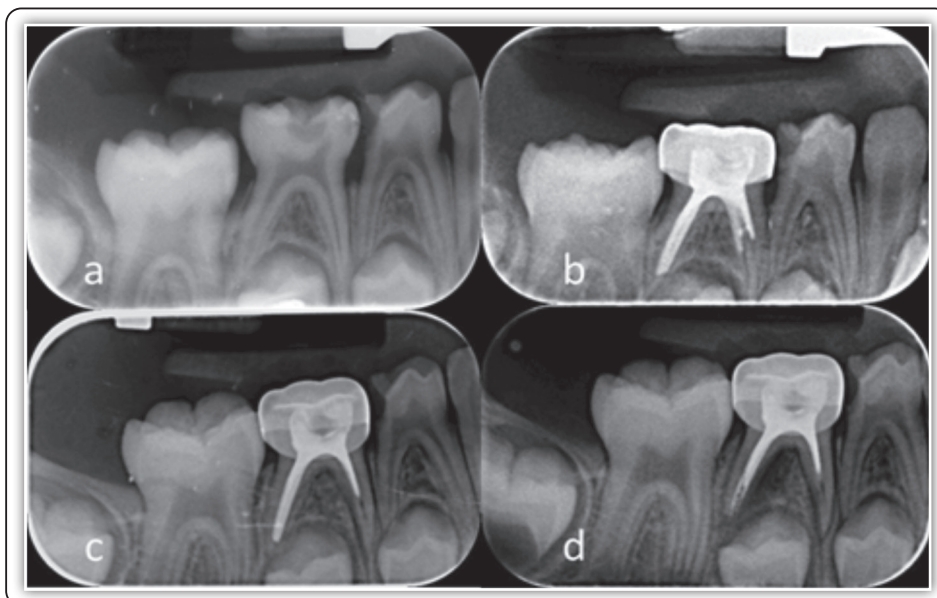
a) Preoperative X-Ray of badly decayed lower right second primary molar. b) Immediate Postoperative X-Ray after partial pulpectomy with Calcium Hydroxide-Iodoform paste using 70% Ethanol Alcohol as an intracanal irrigant. c) 6 Months Follow-up X-Ray showing widening of the periodontal ligaments. d) 12 Months Follow-up X-Ray showing widening of the periodontal ligaments, internal root resorption, interradicular radiolucency, and dissolution of Calcium Hydroxide-Iodoform paste.
